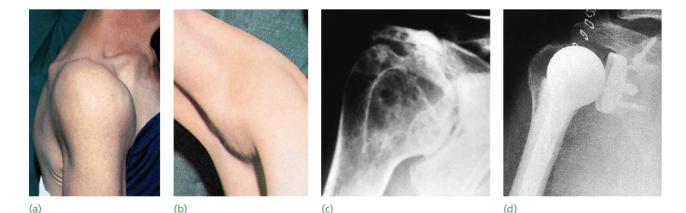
Rheumatoid arthritis (a) Large synovial effusions cause easily visible swelling; small ones are likely to be missed, especially if they present in the axilla (b). (c) X-rays show progressive erosion of the joint. (d) X-ray appearance after total joint replacement.
